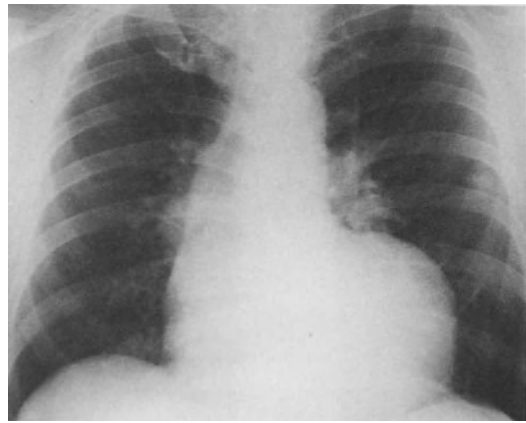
X-ray of the chest showing large post-infarction left ventricular aneurysm.
